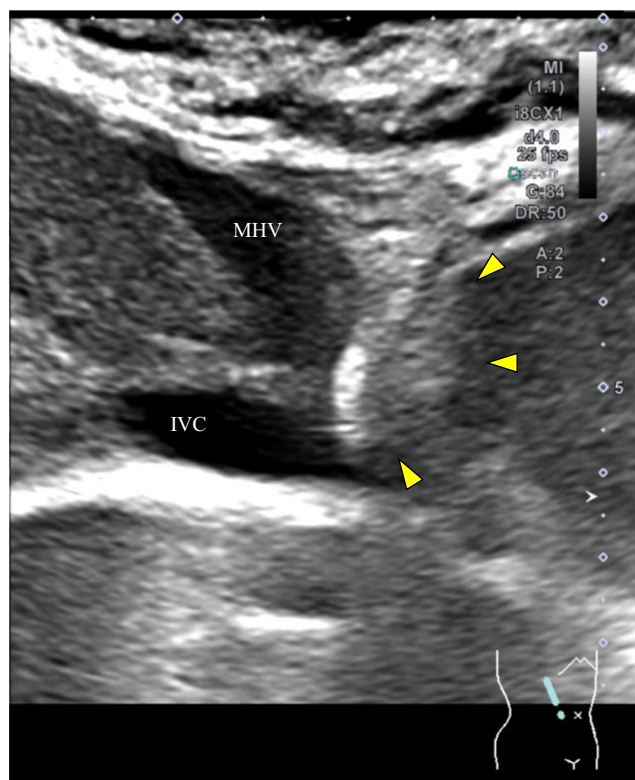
Ultrasonography image showing a smooth, round, 15-mm diameter tumor compressing the middle hepatic vein (MHV) and IVC (yellow arrowheads).
